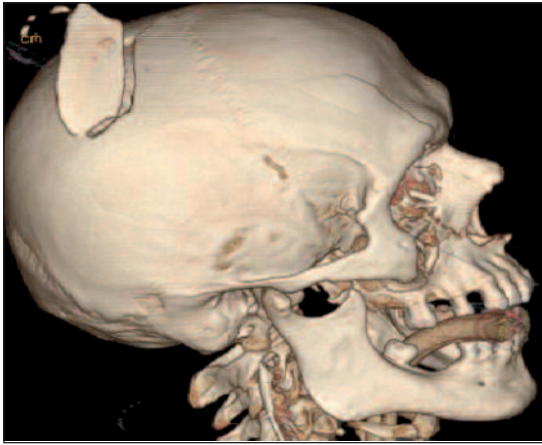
3D computed tomography of the patient showing cranial injury. (See for colored form <http://tipbilimleri.turkiyeklinikleri.com/>)
